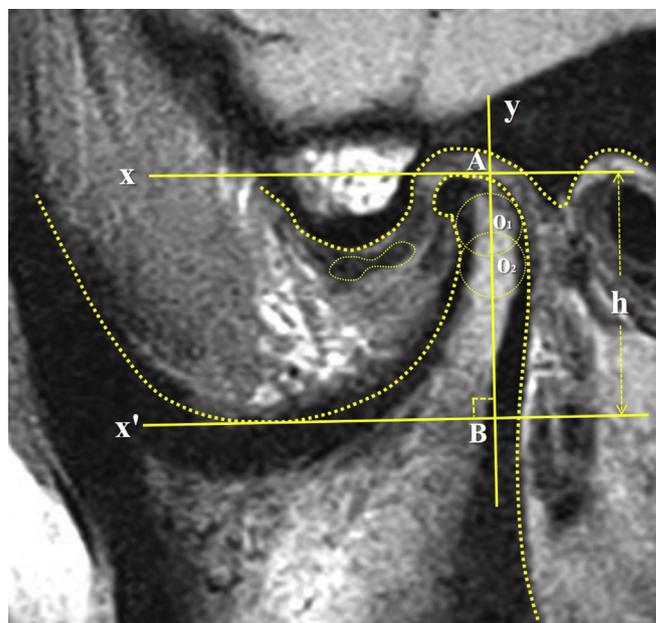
Measurements of condylar height in MRI image.
